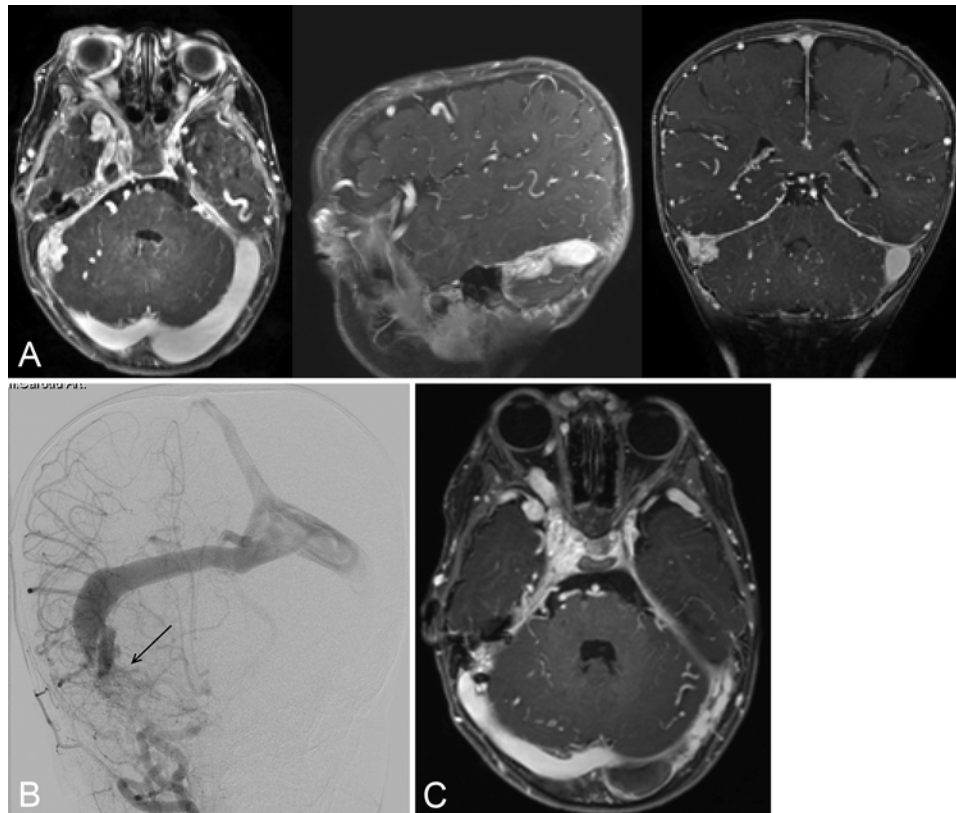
Case 1. A: Axial (left), sagittal (center), and coronal (right) T1-weighted MR images after contrast administration show a dAVM at the right petrous apex with venous engorgement of cortical veins. B: Right common carotid angiogram showing a dAVM (arrow) draining to the right transverse sinus and demonstrating retrograde flow of the superior sagittal sinus. C: Axial T1-weighted postcontrast MR image showing left transverse sinus thrombosis.
